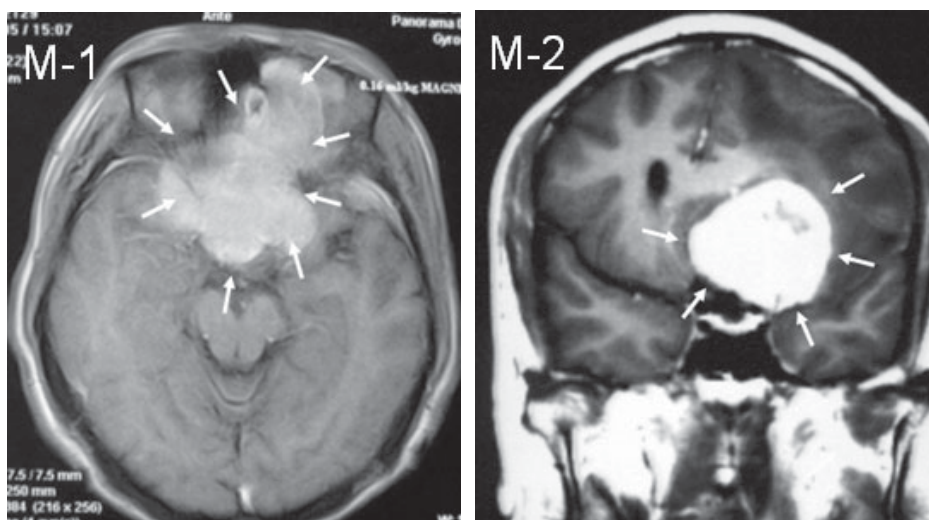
Figure M-1 MRI of case 8 (AP view)- white arrows showed the border of the tumor.
